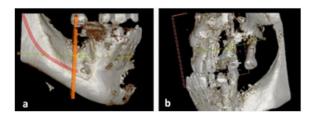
CBCT radiograph
